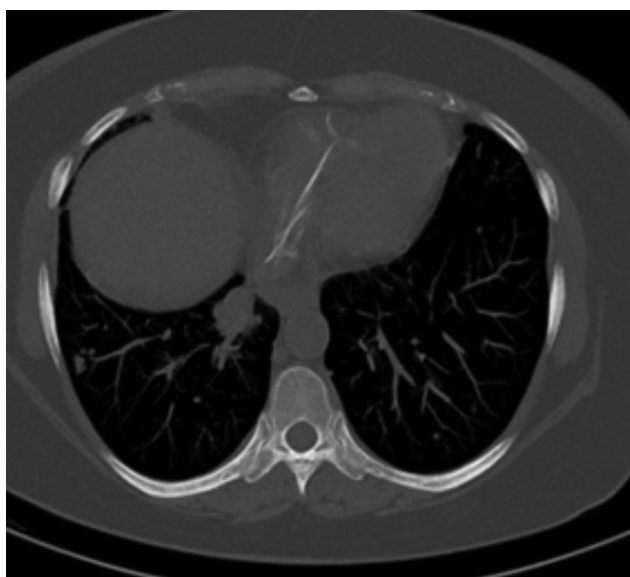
HRCT axial view showed the broken PICC line into the right atrium and right ventricle (yellow arrow). HRCT, high-resolution computed tomography; PICC, peripherally inserted central catheter.
